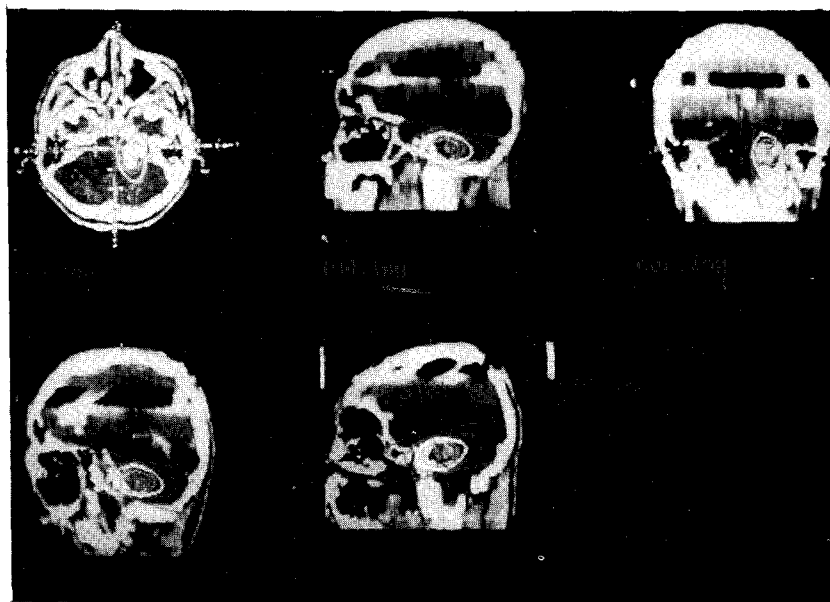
CT images showing head contour, arc paths, and acoustic tumor. Isodose distributions (80, 40, 20, 10% curves) were shown, and 80% isodose curve sufficiently covered the acoustic tumor in all directions of arc, sparing doses of eyes and surrounding normal structures²⁰.
